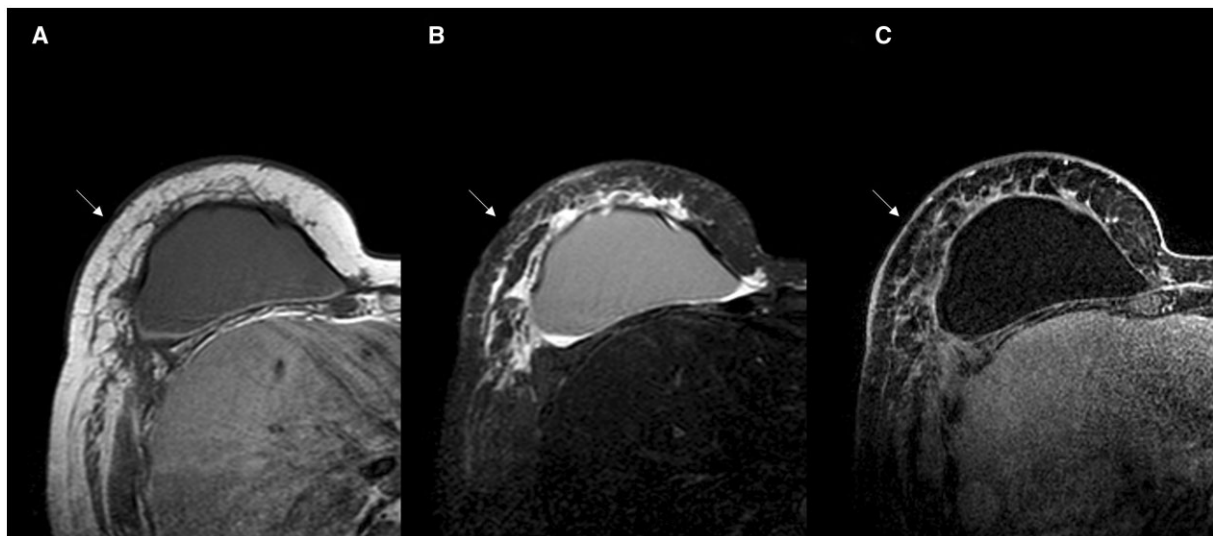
Human acellular dermal matrix (ADM) at MRI: normal findings. Twelve months after implant-breast reconstruction (skin-sparing mastectomy) with human ADM: breast MR imaging may show ADM as isointense periprosthetic layer on T1-weighted imaging (A), hyperintense on T2-weighted imaging (B), on post-contrast DCE sequences, ADM may demonstrate mild or no enhancement (C).
